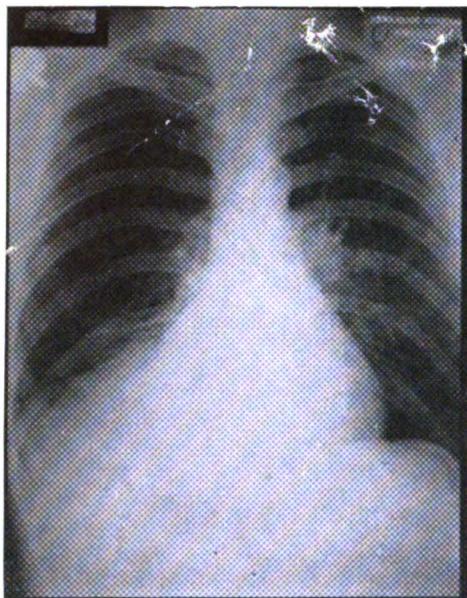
P.A. radiograph of the chest.
